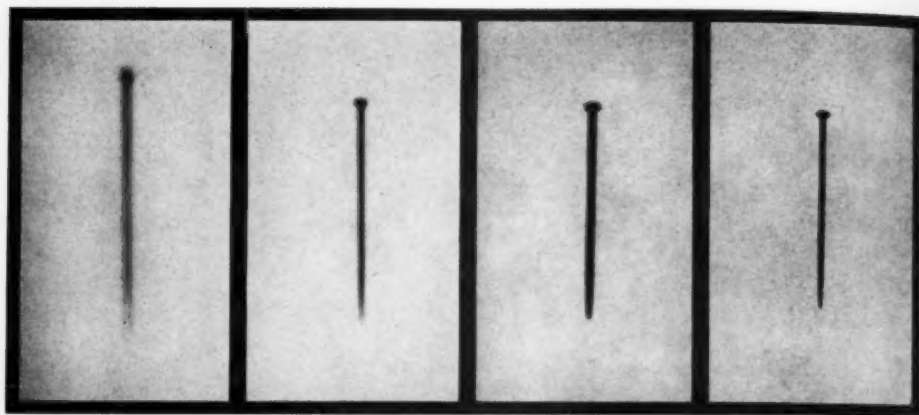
Entirely aside from its salutary effect upon x-ray exposure of the patient's skin (see Fig. 4 and Table I), increase of the target-screen (and target-skin) distance produces marked improvement in sharpness. In each of the four fluoroscopic procedures pictured here, the foreign body, an ordinary straight pin, was 6 inches from the screen. The target-screen distances were, respectively, 16, 25, 30 and 48 inches. The tube was a "round-focus," "radiator" type such as was frequently used ten years ago in oil-immersed, shock-proof fluoroscopes for biplane guidance of the bronchoscopist. With the shorter distances the observed shadow was sometimes entirely penumbral.
